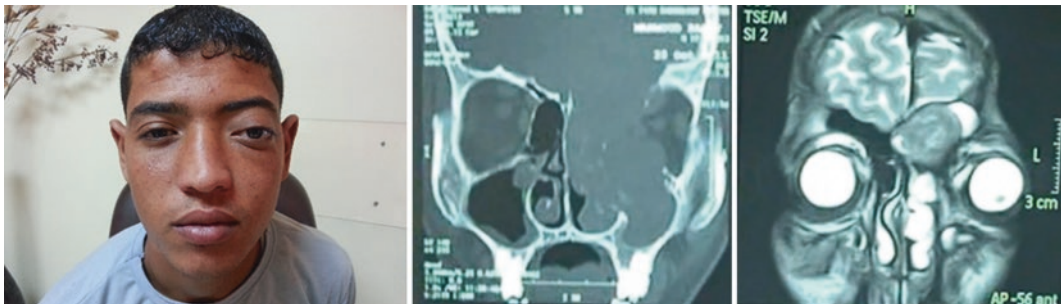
Chronic invasive fungal granuloma, MRI differentiates between the granuloma and retained secretion
